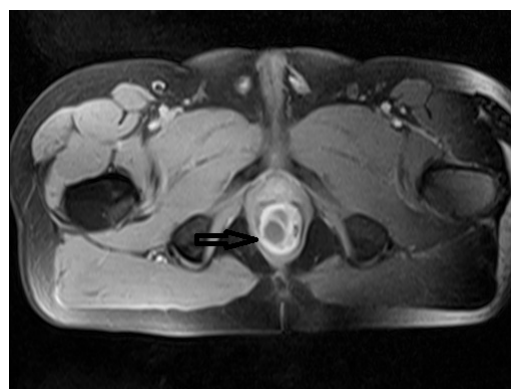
Axial contrast-enhanced T1-weighted image reveals an abscess (arrow) in intersphincteric space resulting from interhemispheric fistula.
